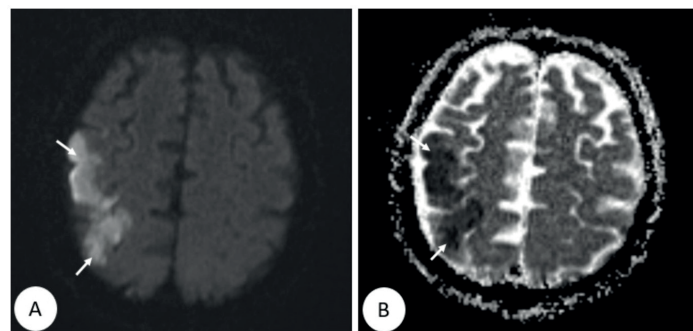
Brain diffusion magnetic resonance imaging showing areas of restricted diffusion compatible with hyperintense infarction in the right frontal lobe (A), and hypointense infarction on apparent diffusion coefficient mapping (B) (arrows).
